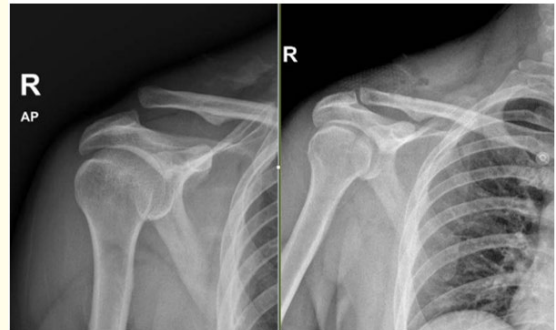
Preoperative (left) and postoperative (right) anteroposterior shoulder x-rays, in which the reduction of the CC and AC joints are confirmed.
